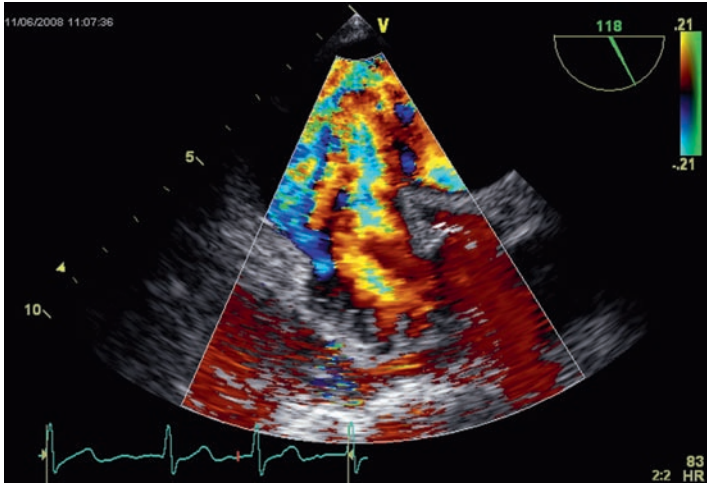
Left atrial appendage imaged in 2D with additional color Doppler at a low aliasing velocity (21 cm/s) demonstrating good flow in all areas.
